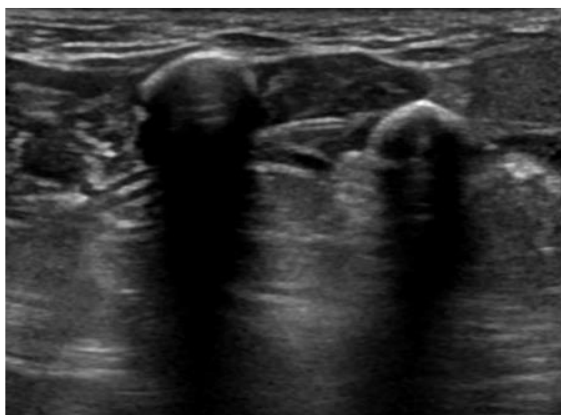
Ultrasound showing encapsulated iso-hyperechoic avascular lesion extended dorsally from the II to the IV metacarpal bone” [36]
